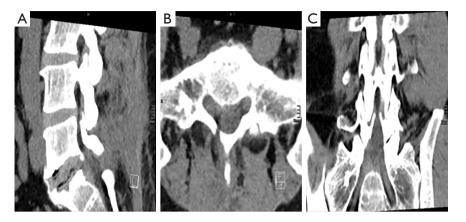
Sagittal (A), axial (B) and coronary (C) CT examination 3 weeks later than imaging studies shown in *Figure 1*, when the patient developed similar symptoms as before the first surgery at our institution.
